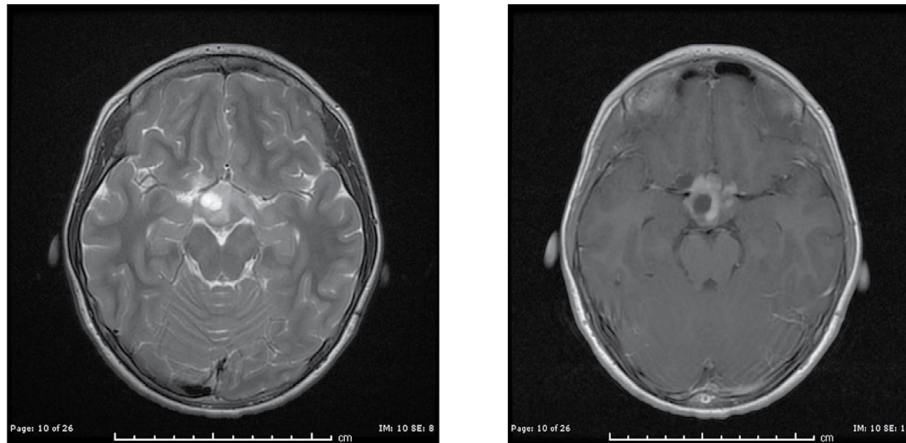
Axial T2 (left) and contrast-enhanced (right) magnetic resonance imaging of a 10 year old girl with NF1 who underwent imaging secondary to headaches. She was found to have a bilateral optic pathway glioma with chiasmal involvement and contrast enhancement. Visual acuity and visual fields were normal at the time this was detected and remained normal without tumor-directed therapy.
